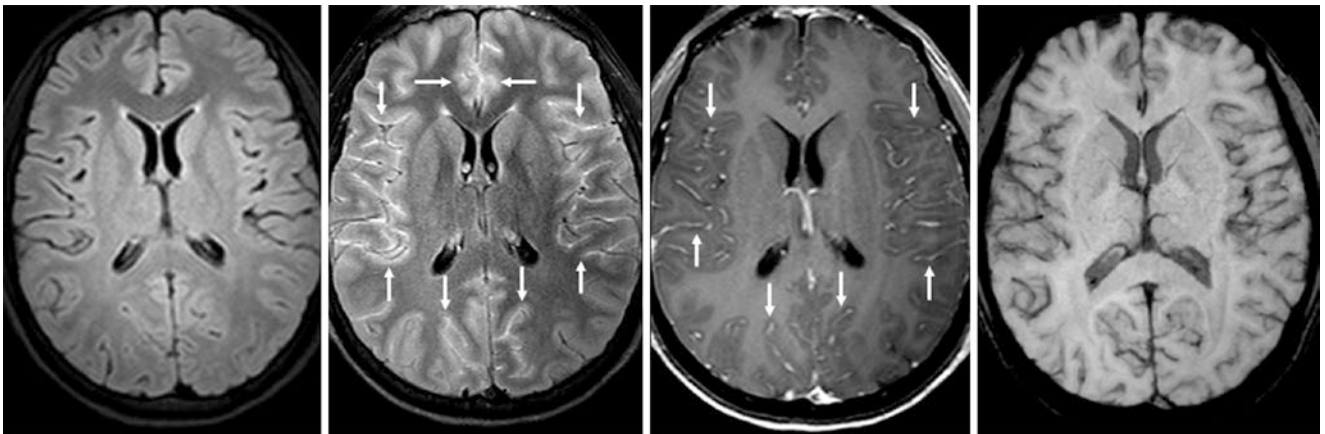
Comparison case of viral (unspecified) meningitis. A 16-year-old immunocompetent female with a severe headache had a normal noncontrast FLAIR at 3T (*left*), but postcontrast FLAIR (*left middle*) and GET1WI (*right middle*) confirmed true LMCE. Note
